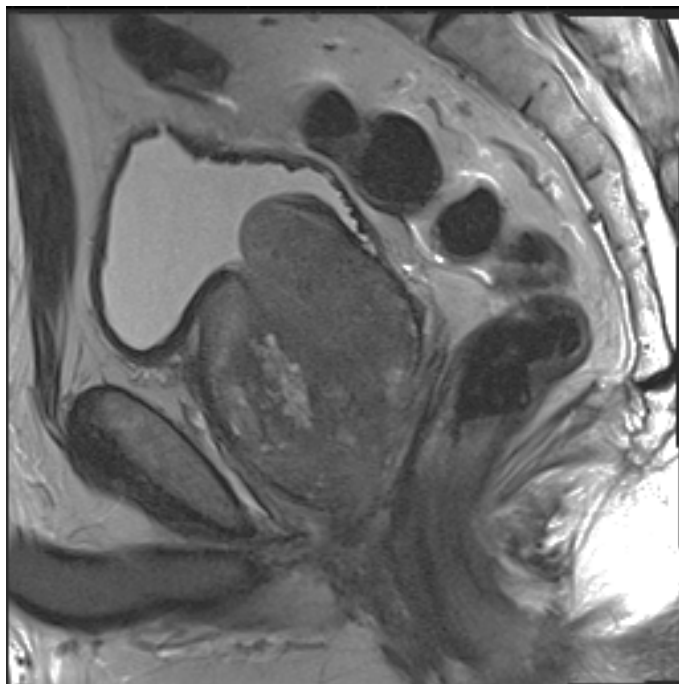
Sagittal and axial MR images of the prostate demonstrating enlarged heterogenous gland consistent with BPH. Total gland volume measured 182 cc, with transitional zone volume of 144 cc.
